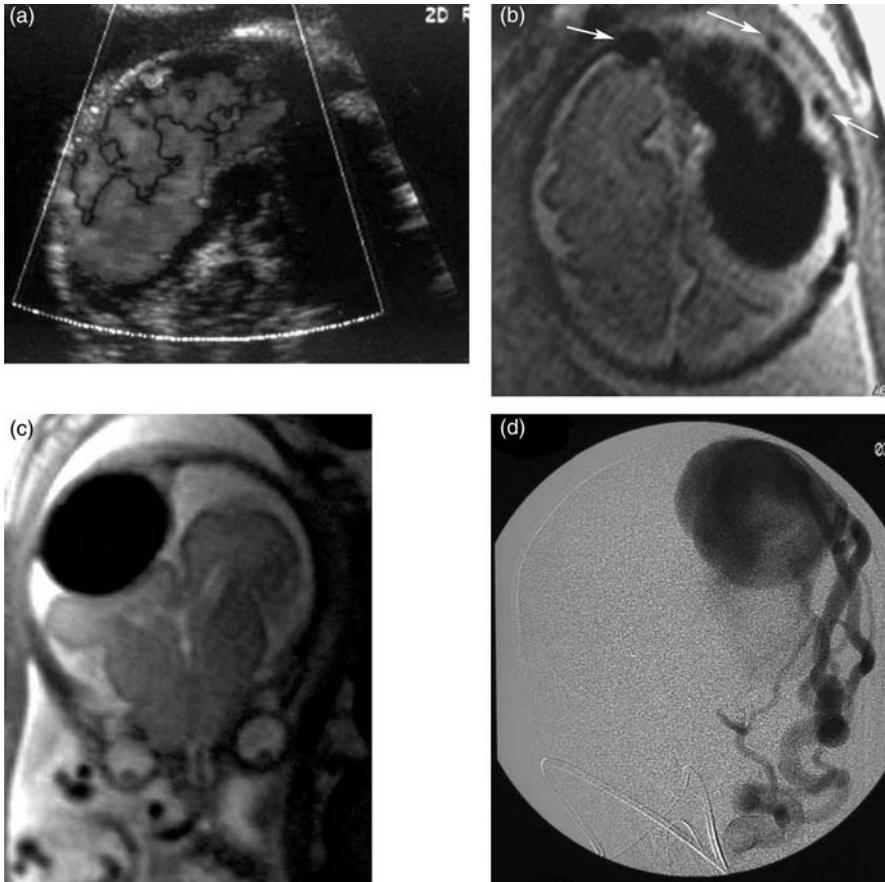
Galenic arteriovenous fistula at 38 weeks gestational age. Transverse color Doppler sonogram (a) shows high flow turbulence (arrows) in the pineal region. Sagittal (b) and oblique coronal (c and d) T<sub>2</sub>-weighted images show the vascular flow voids of the enlarged vein of Galen varix draining into enlarged transverse sinuses as well as a number of prominent arterial feeder flow voids suggesting the choroidal type of Galenic arteriovenous fistula. As a fetus with this type of vascular malformation is at risk for high output congestive heart failure, a cesarean section was performed. Postnatal lateral digital subtraction angiogram (e) confirms the choroidal type of Galenic arteriovenous fistula. [(a, c, and e) From Levine (115)]
